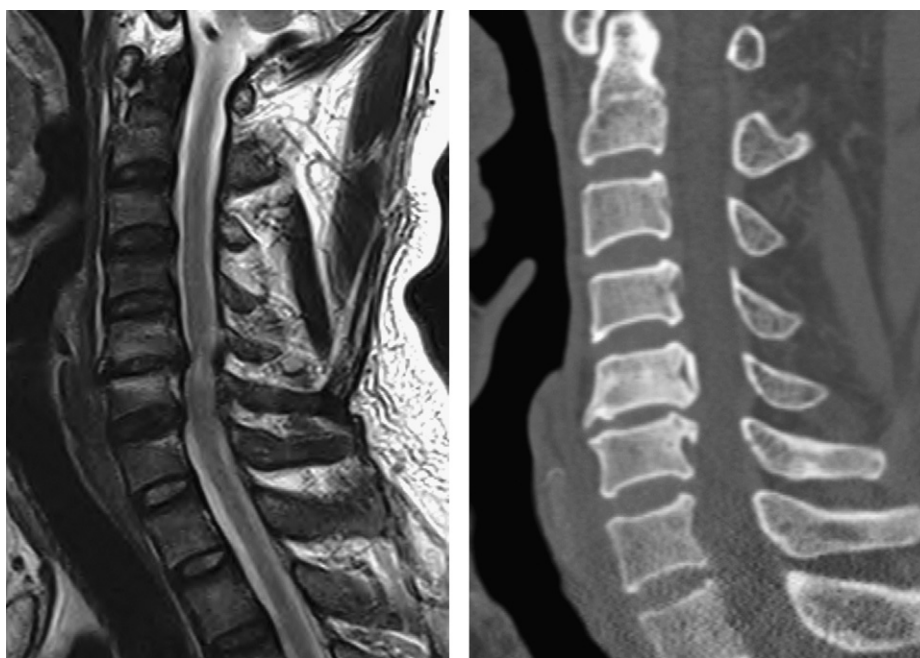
(Left) Preoperative sagittal T2-weighted magnetic resonance imaging of the cervical spine showing spinal stenosis and signal change consistent with myelomalacia at C5–C6. (Right) A sagittal reconstruction of computed tomography scans revealing segmental ossification of the posterior longitudinal ligament.
